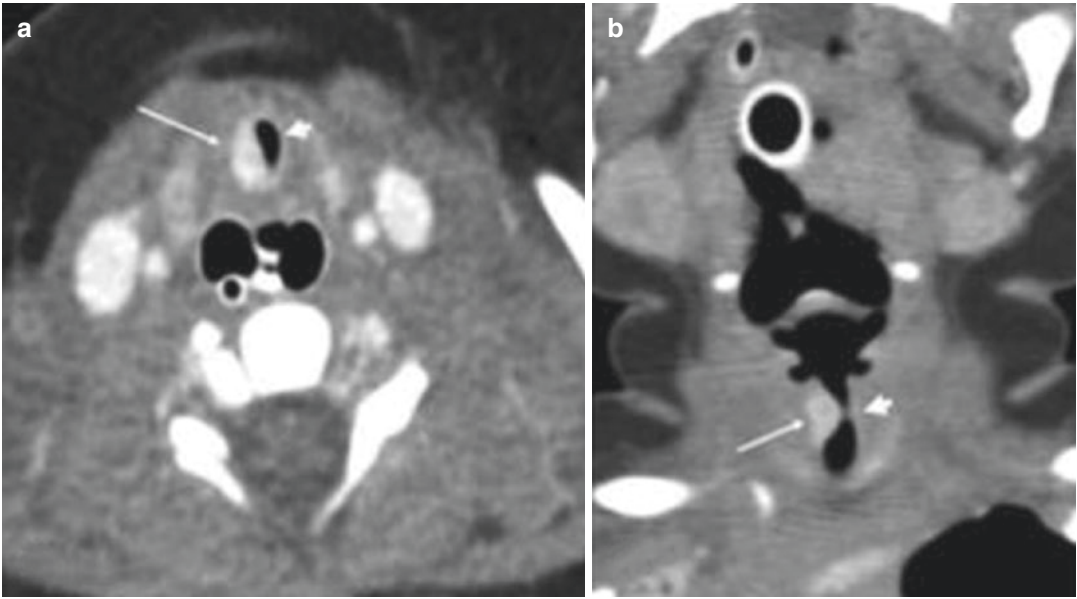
Subglottic hemangioma in a 5-day-old newborn with a progressive stridor. Multidetector helical CT scans obtained after intravenous contrast administration show, in the axial section (a) and coronal reconstruction
